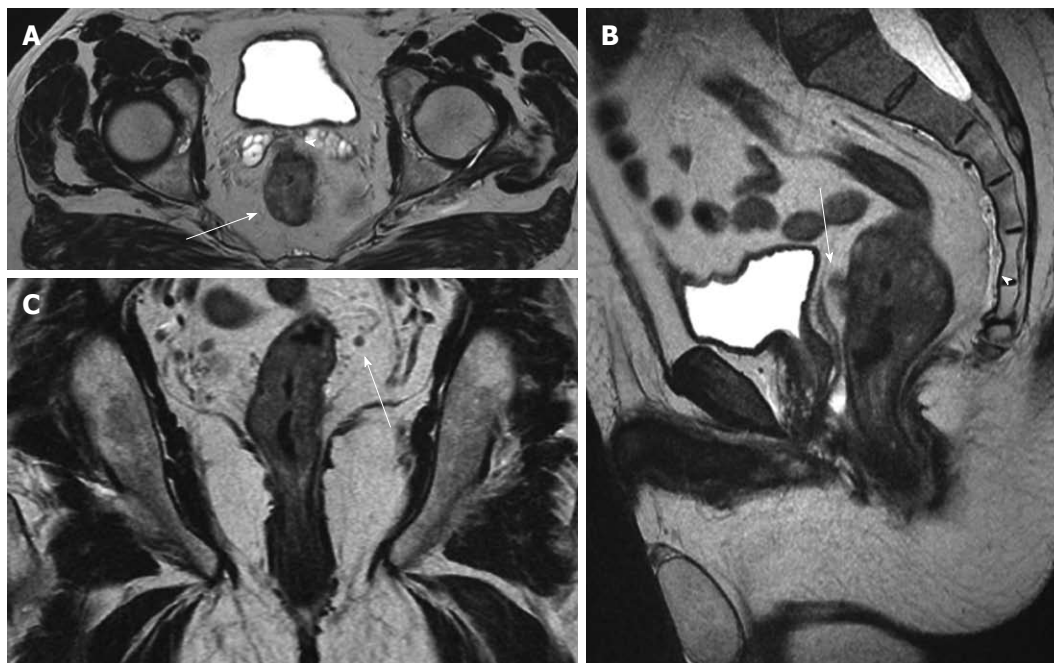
Magnetic resonance imaging staging of rectal cancer before chemoradiation: T3, N+. Pathology result: T3, N1. A: Axial T2w image shows the circumferential tumor (arrow) and the extramural spread anteriorly (arrowhead) close to the seminal vesicles; B: In the sagittal T2w image, the anterior extramural spread (arrow) can be also recognized close to the mesorectal fascia (thin vertical hypointense line posterior to the bladder). The presacral fascia can also be appreciated (arrowhead) continuing inferiorly as the rectosacral fascia; C: In the coronal T2w image, a small mesorectal lymph node (arrow) is seen.
